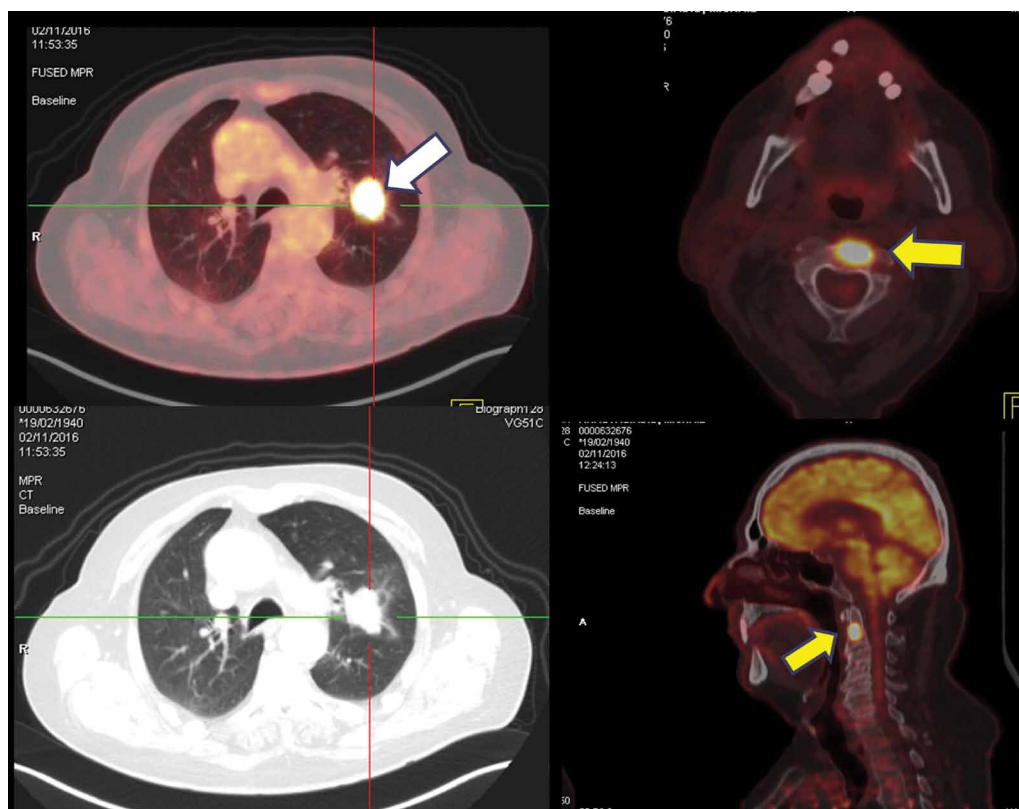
Metastatic lung cancer. Hypermetabolic left lung cancer mass (white arrow) with a solitary FDG-avid metastatic bone lesion in C2 vertebra (yellow arrow).
